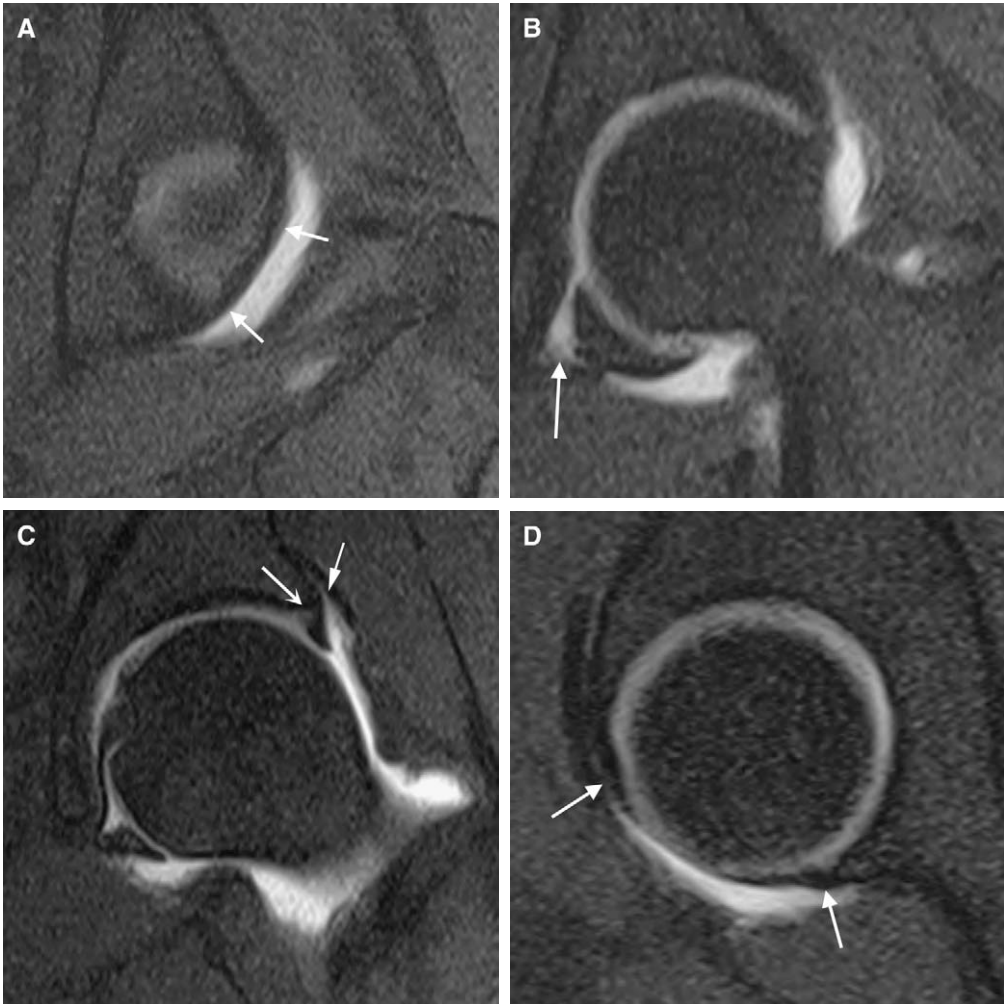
Normal anatomy with intra-articular gadolinium. Coronal fat saturated T1-weighted images from posterior to anterior (A–C) demonstrate the attachment of the labrum along the posterior rim (A, arrows) and the labroligamentous sulcus at the posteroinferior corner of the joint where labrum and transverse ligament join (B, arrow). The normal attachment of the superior labrum to the acetabular rim is seen (C, arrow with curved head) and no separation between the labrum and articular cartilage is evident. The normal perilabral sulci are seen, superiorly where it is larger (C, arrow with straight head) and posteriorly where it is smaller (E, arrowhead). On the sagittal fat-saturated T1-weighted image (D) the normal labrum blends imperceptibly with the transverse ligament (arrows). The posterior perilabral recess is small; the anterior recess (to the left) is barely perceptible. The oblique axial gradient echo image (E) also demonstrates the normal labral attachment (arrow with straight head). In this image, a portion of the labrum overlies the articular cartilage. Contrast material has entered the iliopsoas bursa medial and lateral to the iliopsoas tendon (arrows with curved heads). This communication is normal.
